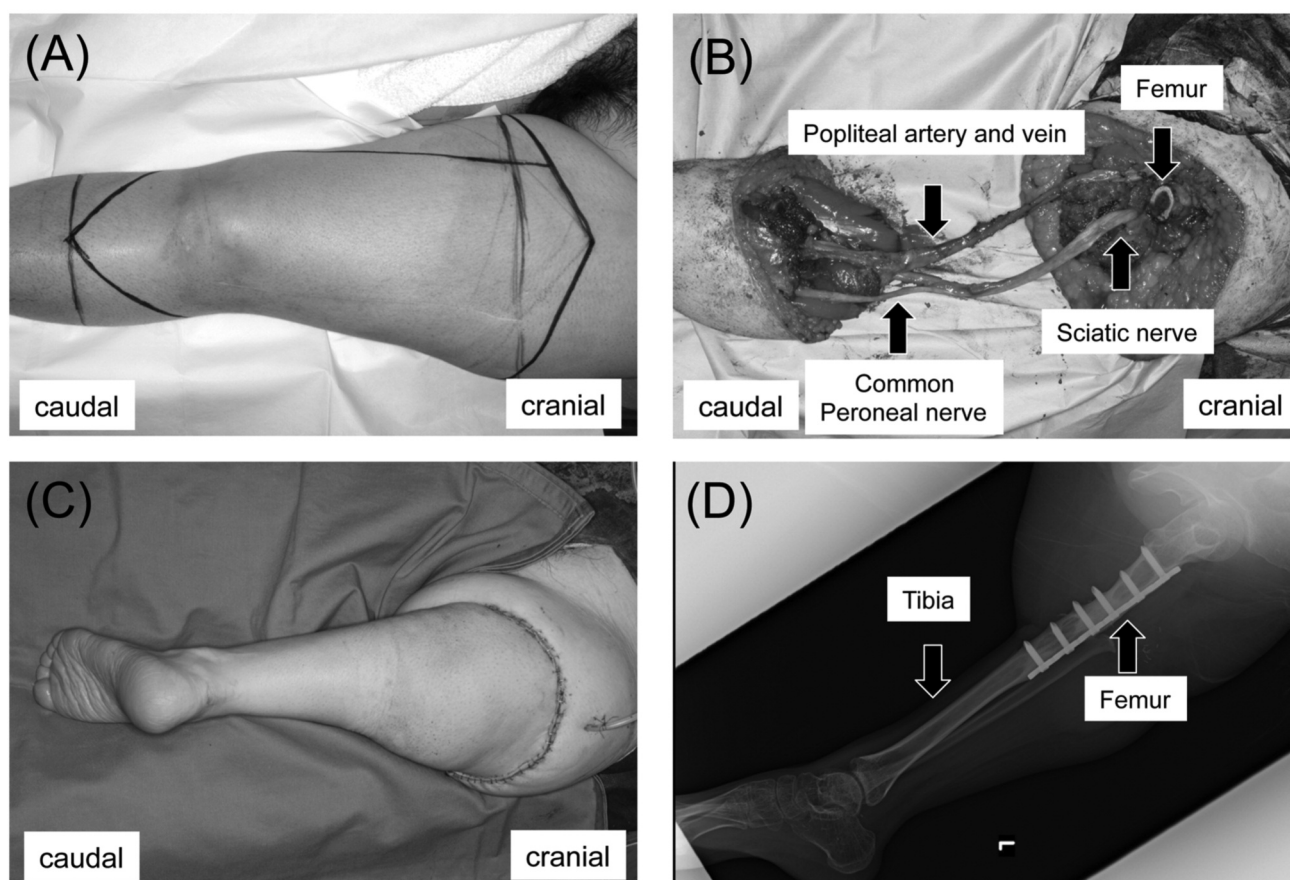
Intraoperative photographs and postoperative X-rays of knee rotationplasty (KRP). (A) Frontal view of preoperative skin incision line. (B) Intraoperative photograph of KRP. Popliteal artery, popliteal vein, common peroneal nerve, and sciatic nerve were conserved. (C) Reconstruction of the knee extension mechanism using the triceps surae. The ankle joint is rotated 180° and sutured to the thigh. (D) Postoperative X-rays of KRP. Tibia and femur were fixed by internal plate.
